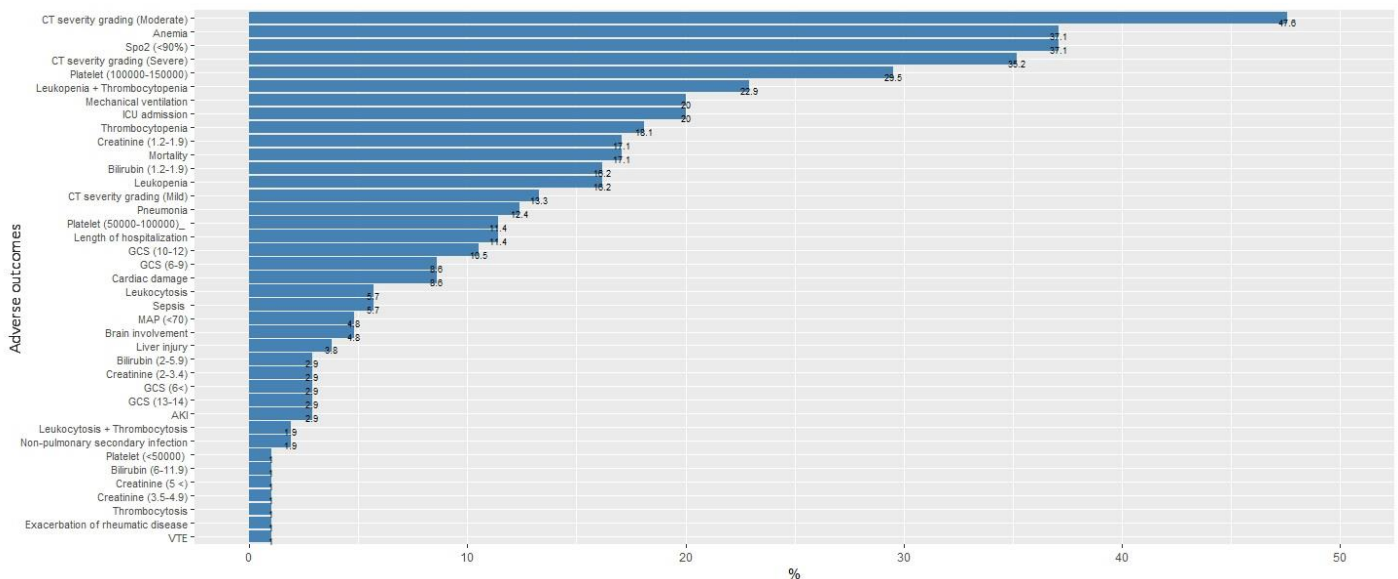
Adverse COVID-19 outcomes among hospitalized patients with rheumatic diseases. SpO2, peripheral oxygen saturation; AKI, acute kidney injury; VTE, venous thromboembolism; ICU, intensive care unit; CT, computed tomography; GCS, Glasgow Coma Scale; MAP, mean arterial pressure.
